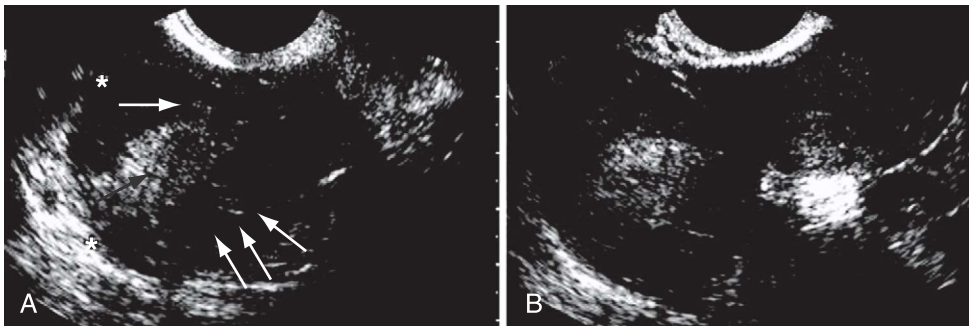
A and B, Intraovarian hemorrhage (arrows in A) in patient with ovarian torsion. (From Andreotti RF, Shadinger L, Fleischer A: The sonographic diagnosis of ovarian torsion: Pearls and pitfalls. *Ultrasound Clin* 2:155, 2007.)
